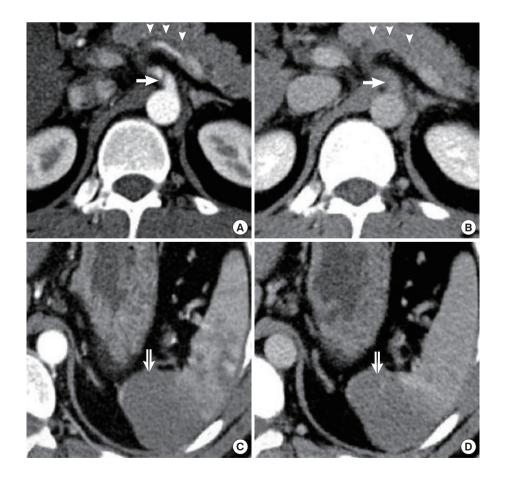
(A) Computed tomography angiography scan shows celiac trunk dissection (arrow) and splenic artery dissection with mural thrombi (multiple arrowheads) in the arterial phase. (B) A portal venous phase image was obtained at the same level. (C) Computed tomography angiography image in the arterial phase demonstrates partial splenic infarction (double arrow). (D) Axial image at the same level was obtained in the portal phase.
